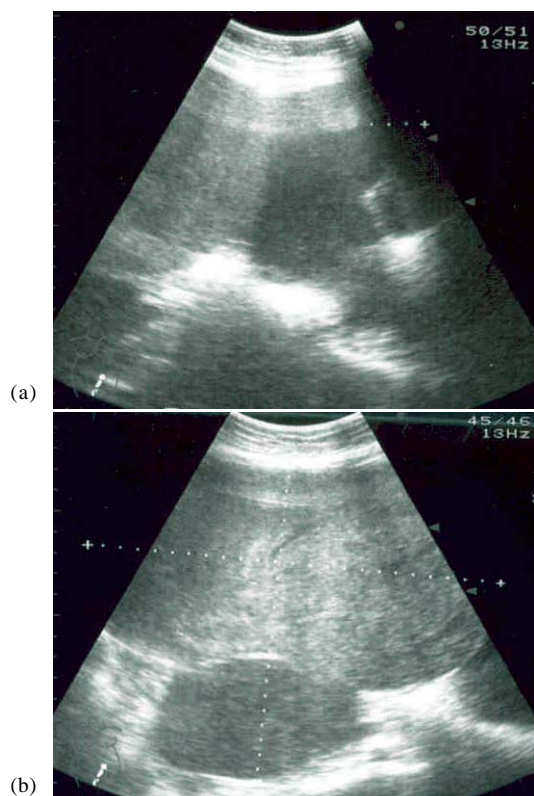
Transabdominal ultrasound demonstrated a normal size uterus with multiple myoma, a partly cystic (a) and partly solid (b) ovarian mass of 27.5 x 15.4 cm
